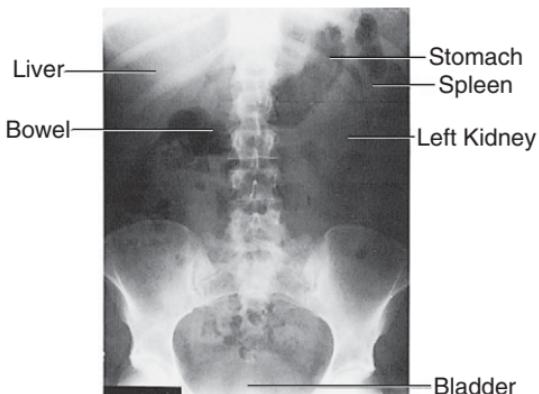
Note that specific organs can often be delineated on the supine abdominal radiograph.
